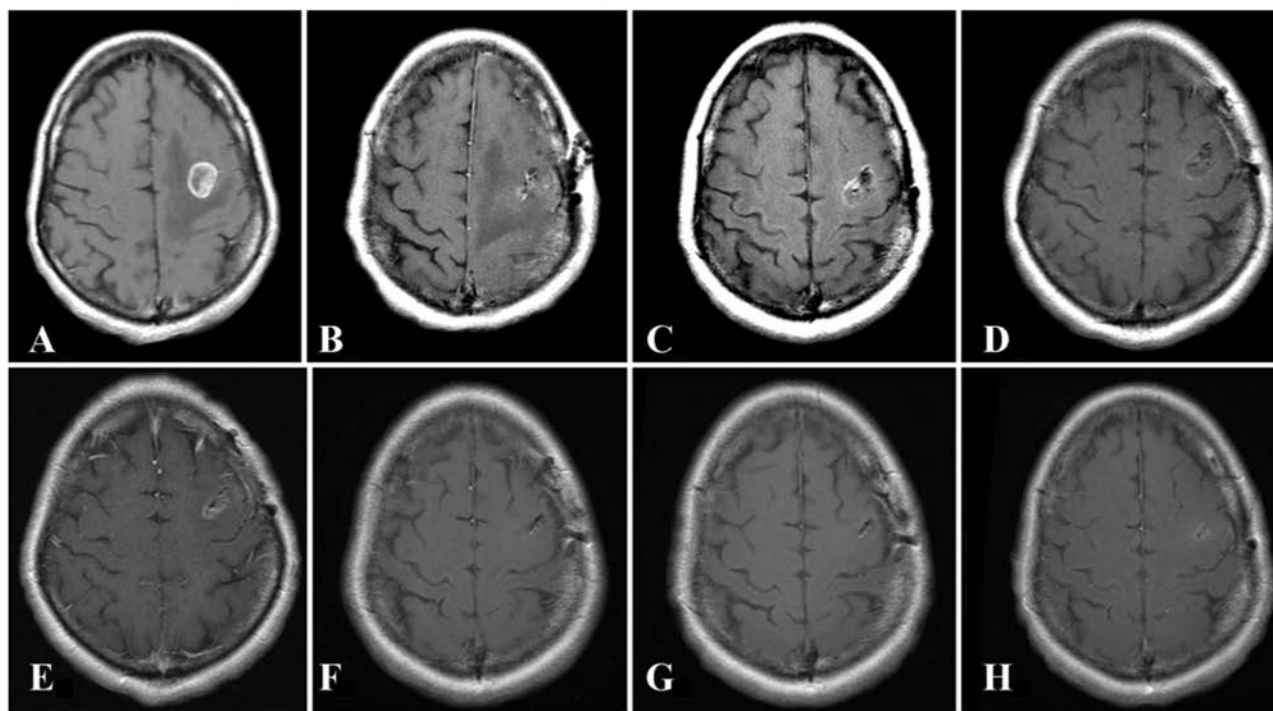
Magnetic resonance imaging series of local FFP. A: Preoperative. B: Postoperative. C: One month postoperative. D: Two months postoperative. E: Four months postoperative. F: Six months postoperative. G: Eleven months postoperative. H: Thirteen months postoperative.
